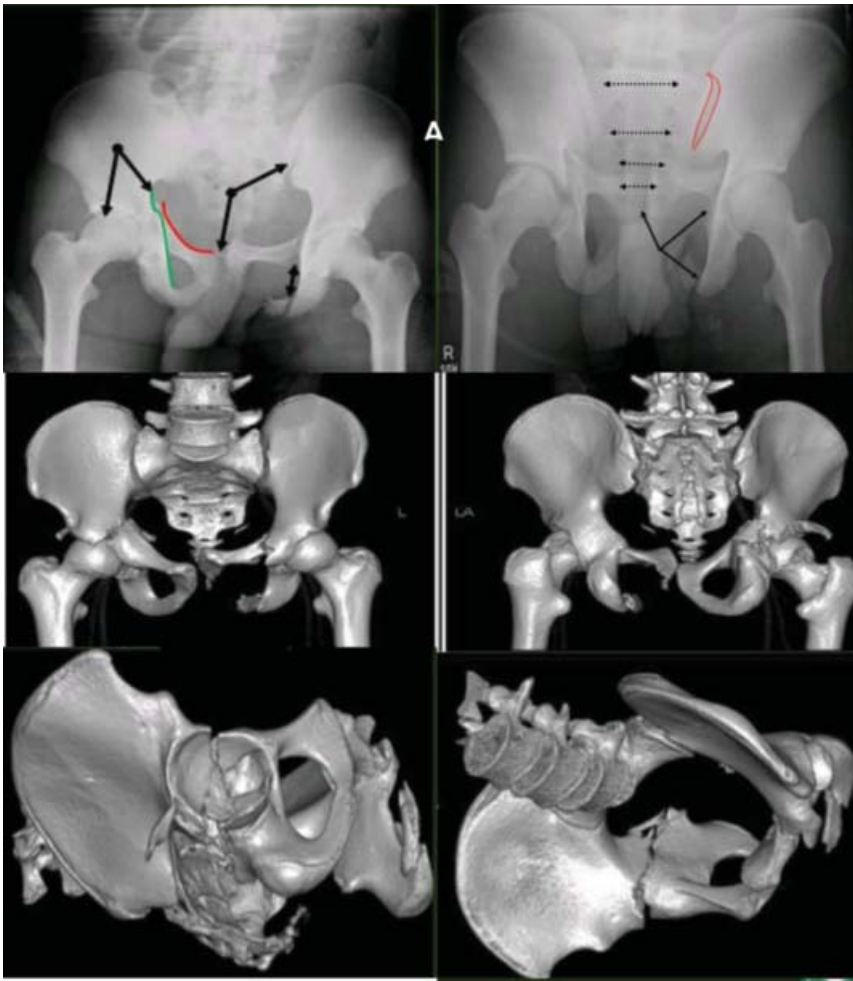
A 17 Years old boy presented to Emergency Department after a run over injury by truck, vitals, abdominal and rectal examination was unremarkable. He was catheterized and no hematuria was present. Trauma team cleared the patient for surgery. A: Preoperative radiographs showing right acetabulum transverse comminuted fracture, anterior column disruption, left pubic rami fracture and sacroiliac joint disruption. B: CT scan of pelvis with 3D reconstruction confirming the findings and helping in preoperative planning.
